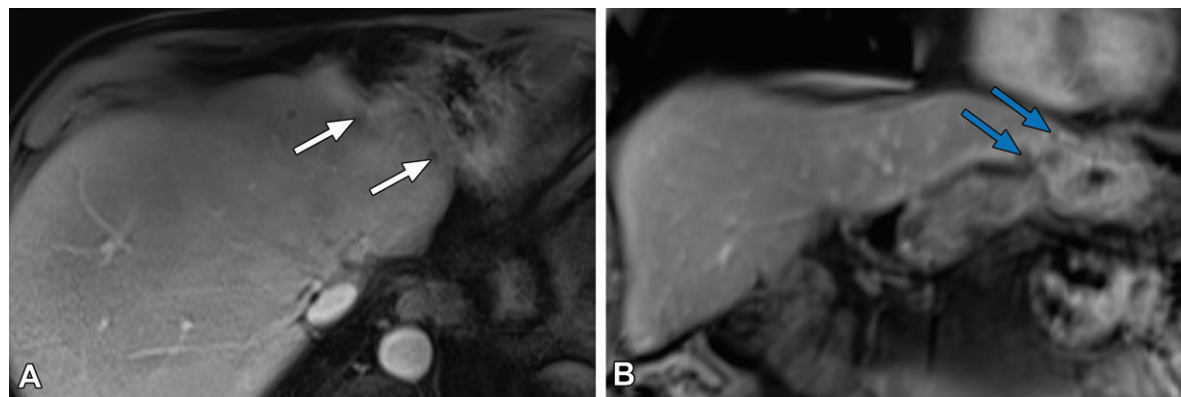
Subtle left lateral section hepatic lesions in a 71-year-old man with HCC after radioembolization. (A) Axial T1-weighted MR image shows that evaluation of the margin of the left lateral section of the liver is often challenging at axial T1-weighted MRI owing to volume averaging with the stomach and cardiac pulsation artifacts. Two small lesions are present (arrows) but were not initially identified. (B) Coronal T1-weighted delayed phase MR image shows the lesions to better advantage (arrows), prompting reassessment at axial imaging.
